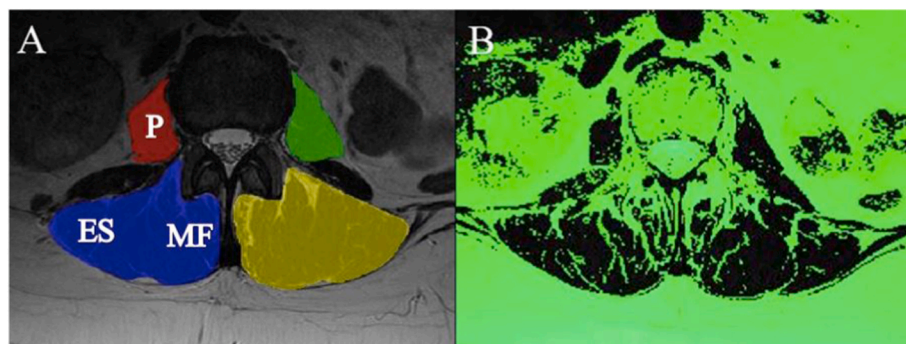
Radiographic muscle measurements at L3 in a 60 y/o female patient. A: Bilateral manual segmentation of psoas (P) and posterior paraspinal muscles (*erector spinae* (ES) and *multifidus* (MF)) on axial T2-weighted MRI. B: Pixels above the automated pixel intensity threshold (high intensity pixels). Low intensity pixels (shown in dark) were used to calculate the functional cross-sectional area of muscles.
